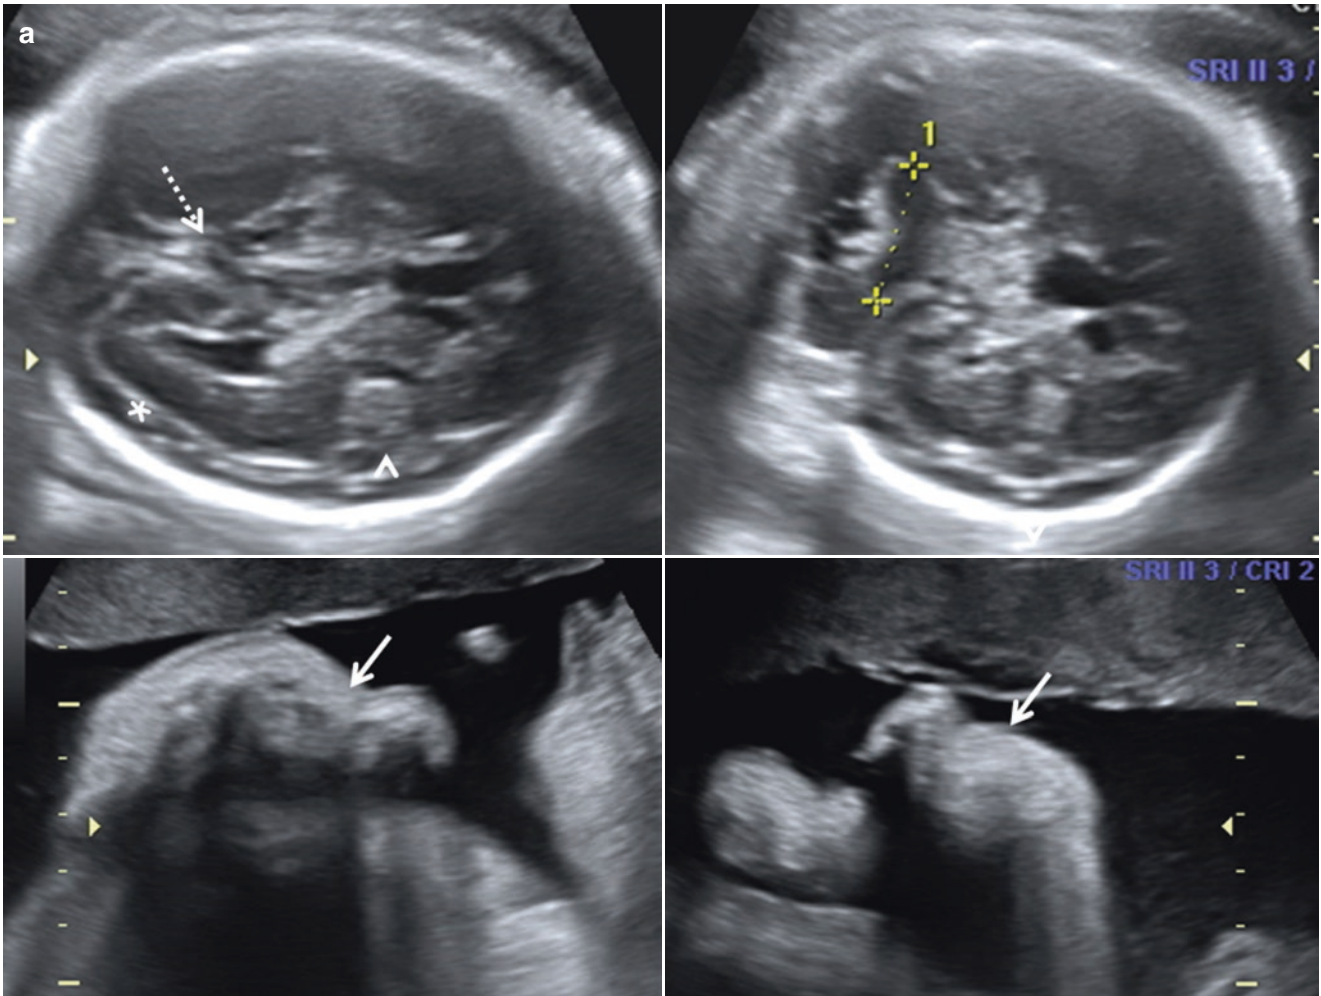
(a) 25 weeks (TAS and MRI) *lissencephaly with partial agenesis of corpus callosum, dilated cystic fourth ventricle, sinus pericranii and persistent primitive falcine vein* – transventricular and mid-sagittal US and T2W sections – shallow parieto-occipital sulcus (arrowheads) and obtuse-angled lateral fissure (dotted arrows), splenium of CC is absent, posterior limit of CC (solid arrow) does not overlie the tectal plate, dilated fourth ventricle (\*), the vermis is posteriorly displaced (V), its size is normal (cephalocaudal dimension of 1.3 cm
